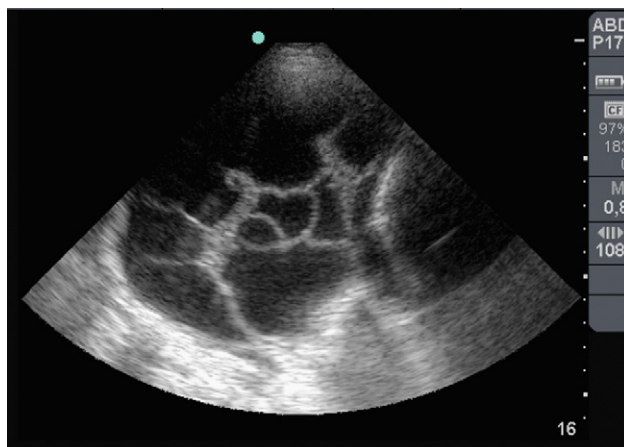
Multiple septations on ultrasonography in a patient with a complicated parapneumonic effusion.
